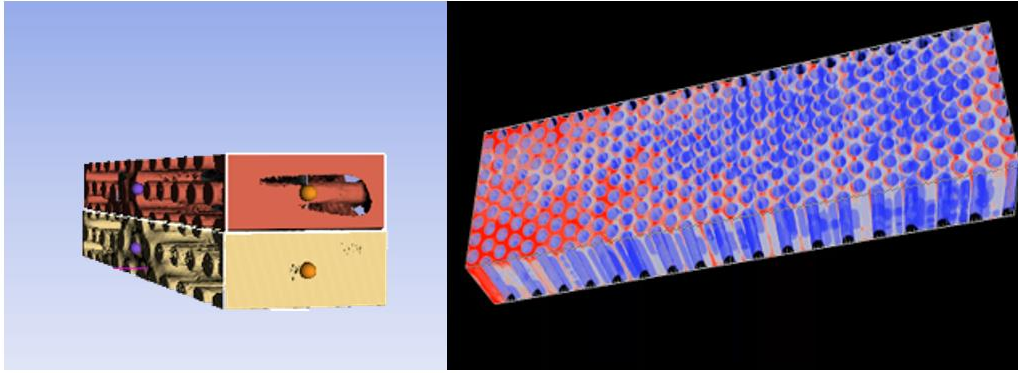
An image of the 3D reconstruction of a μ CT scan in Slicer 4 software (A). These are then averaged with other scans, and the rods in the chamber are subtracted to create the 3D probability map of where clot is most likely to form, red being more likely and blue less likely (B).
